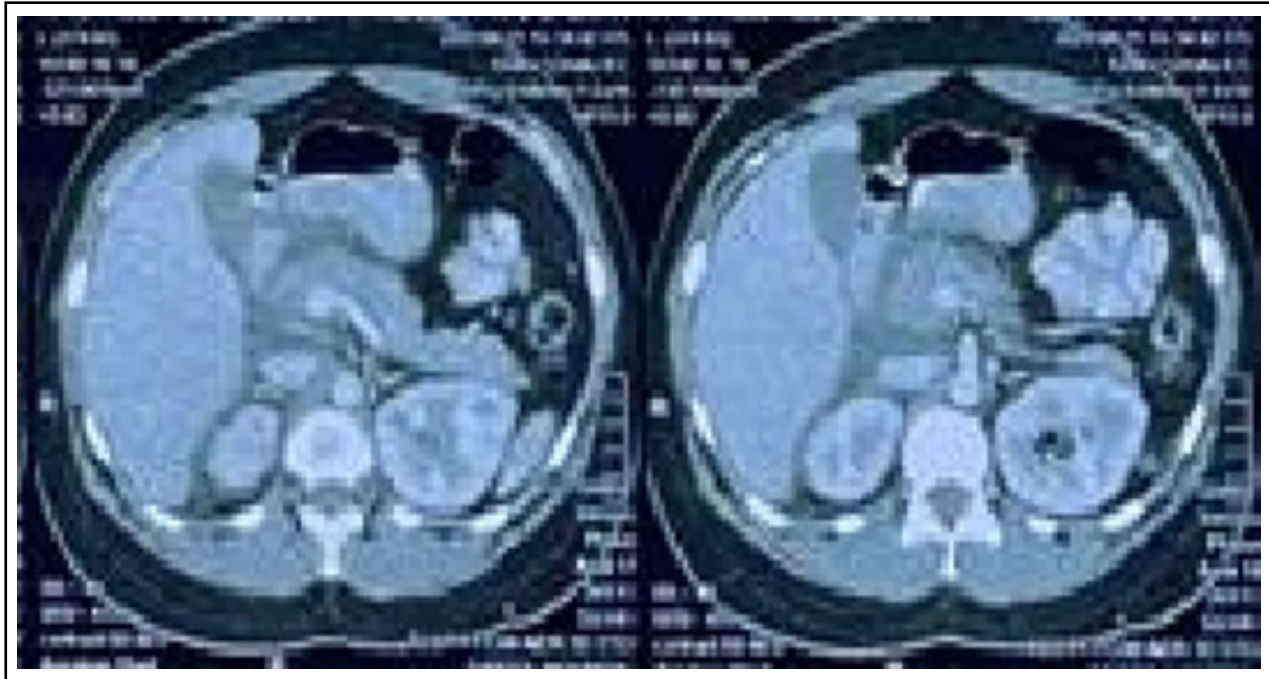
Contrast-enhanced CT scan demonstrating non-necrotizing acute interstitial pancreatitis with a CT severity index of 6.
